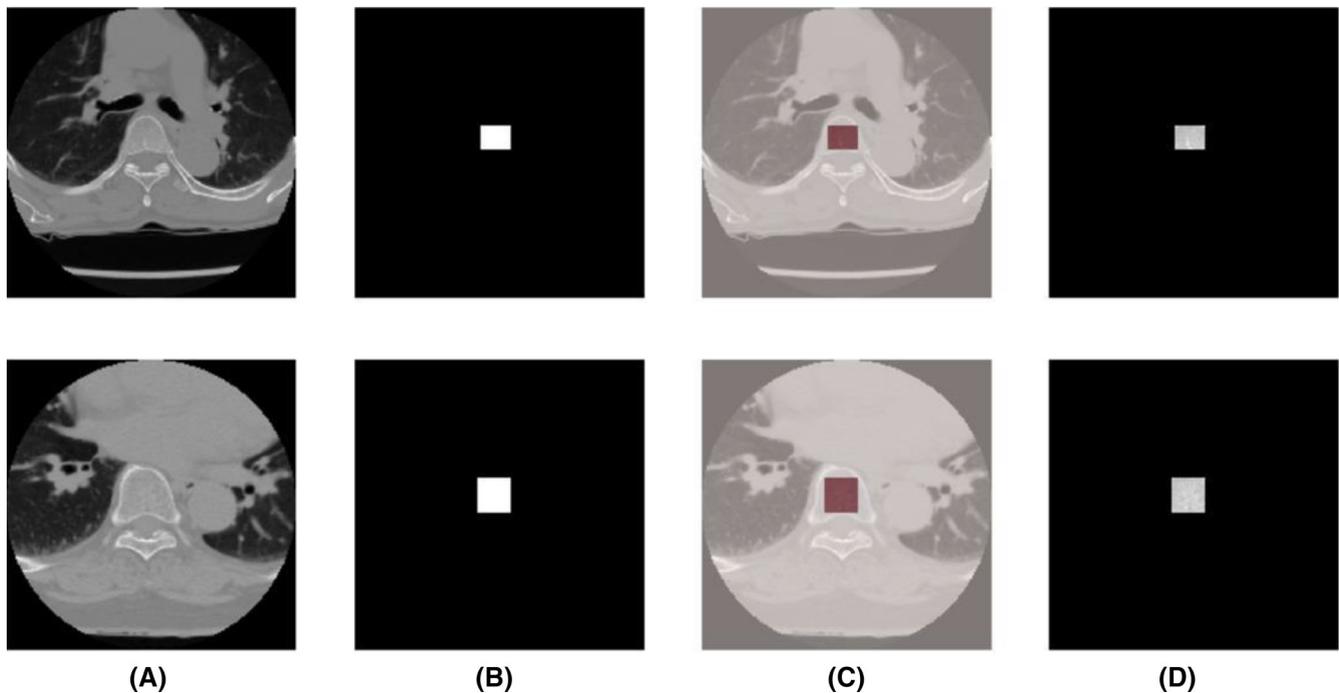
The process of extracting region of interest (ROI) using rectangle ROI mask. A, Normalized computed tomography image. B, Rectangle ROI mask. C, Overlay mask on image. D, Target region
